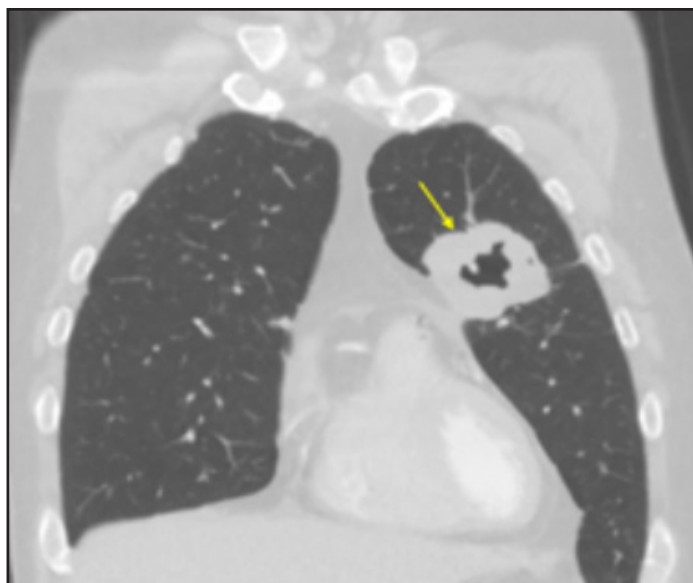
Pyoderma gangrenosum.* Coronal contrast-enhanced CT of a patient with pyoderma gangrenosum demonstrates a thick-walled cavitary lesion (yellow arrow). Extracutaneous involvement was suspected considering the lesion was sterile and negative for malignancy on biopsy.
